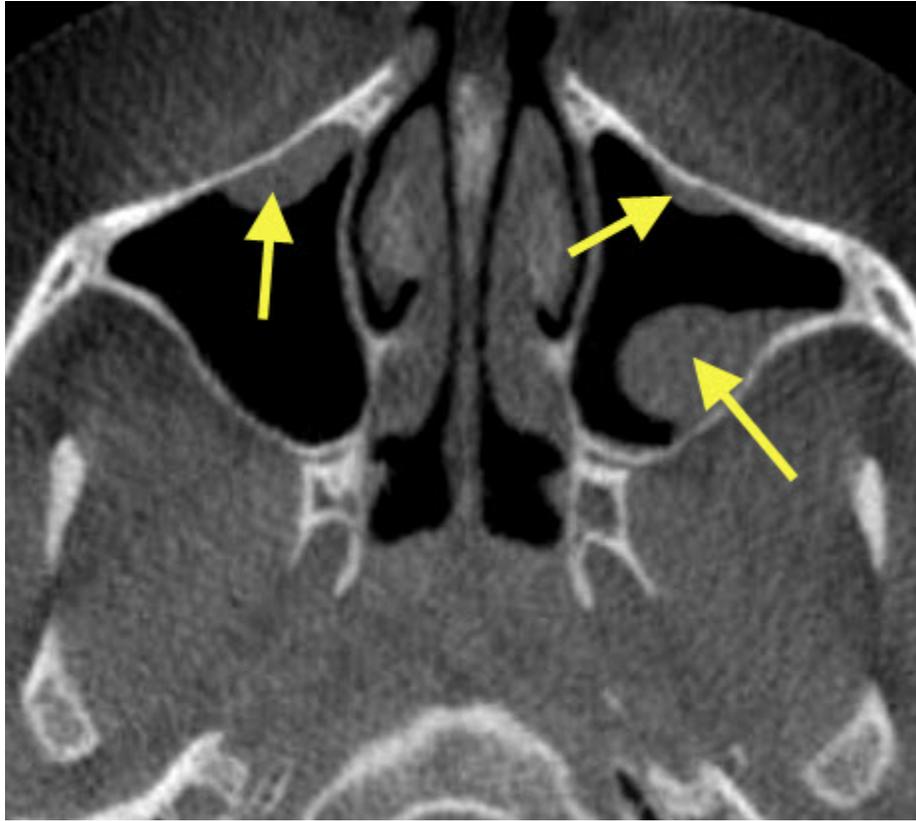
CBCT axial section showing a polypoid mucosal thickening (arrows) in the right and left maxillary sinuses
